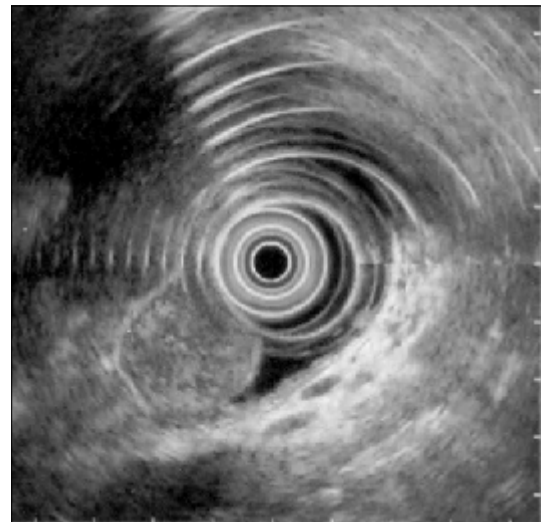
Endoscopic ultrasonography Image of carcinoid tumor at the ampulla of Vater.
